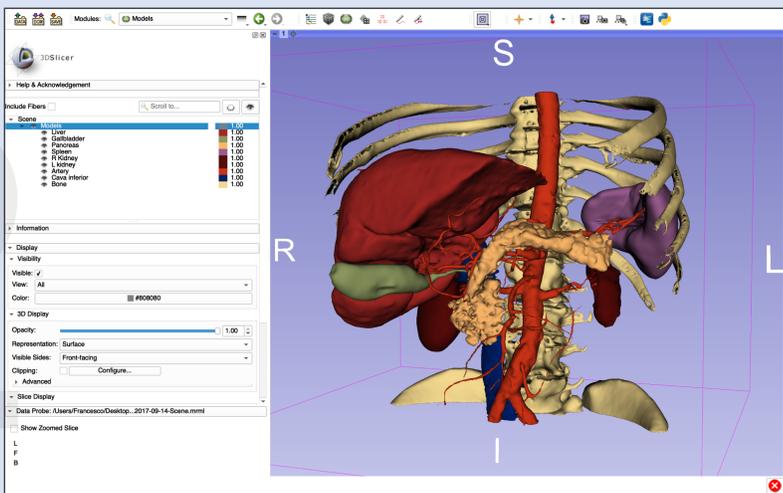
The CT/MRI is three-dimensionally reconstructed in 3D Slicer
